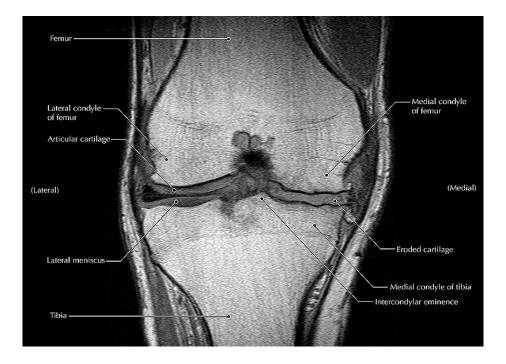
MRI imaging of the knee joint. Coronal view (Sharma et al., 2014).
